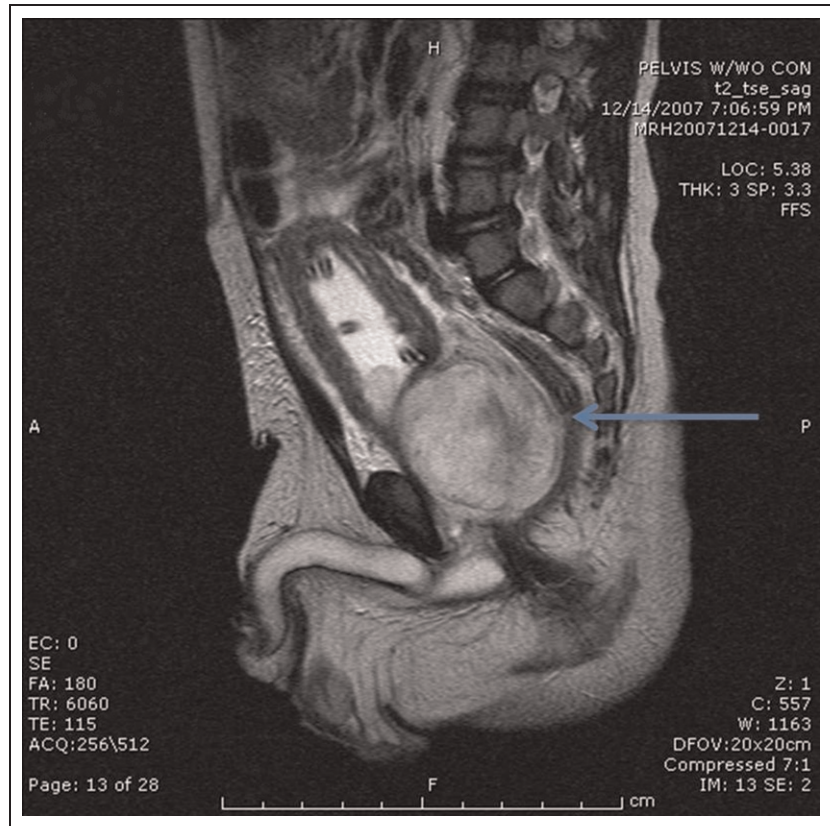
Pelvic MRI showing a mass involving the prostate.
